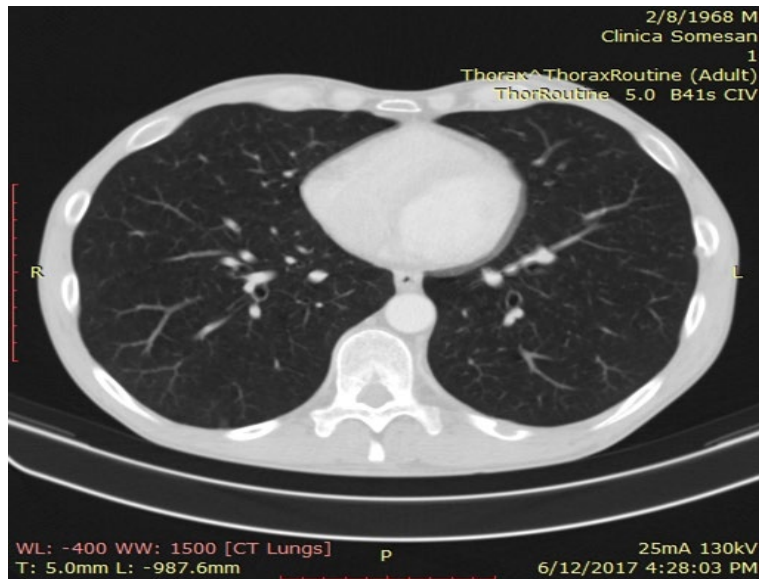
CT scan: Osteolytic lesion on the posterior region of the 10th rib
